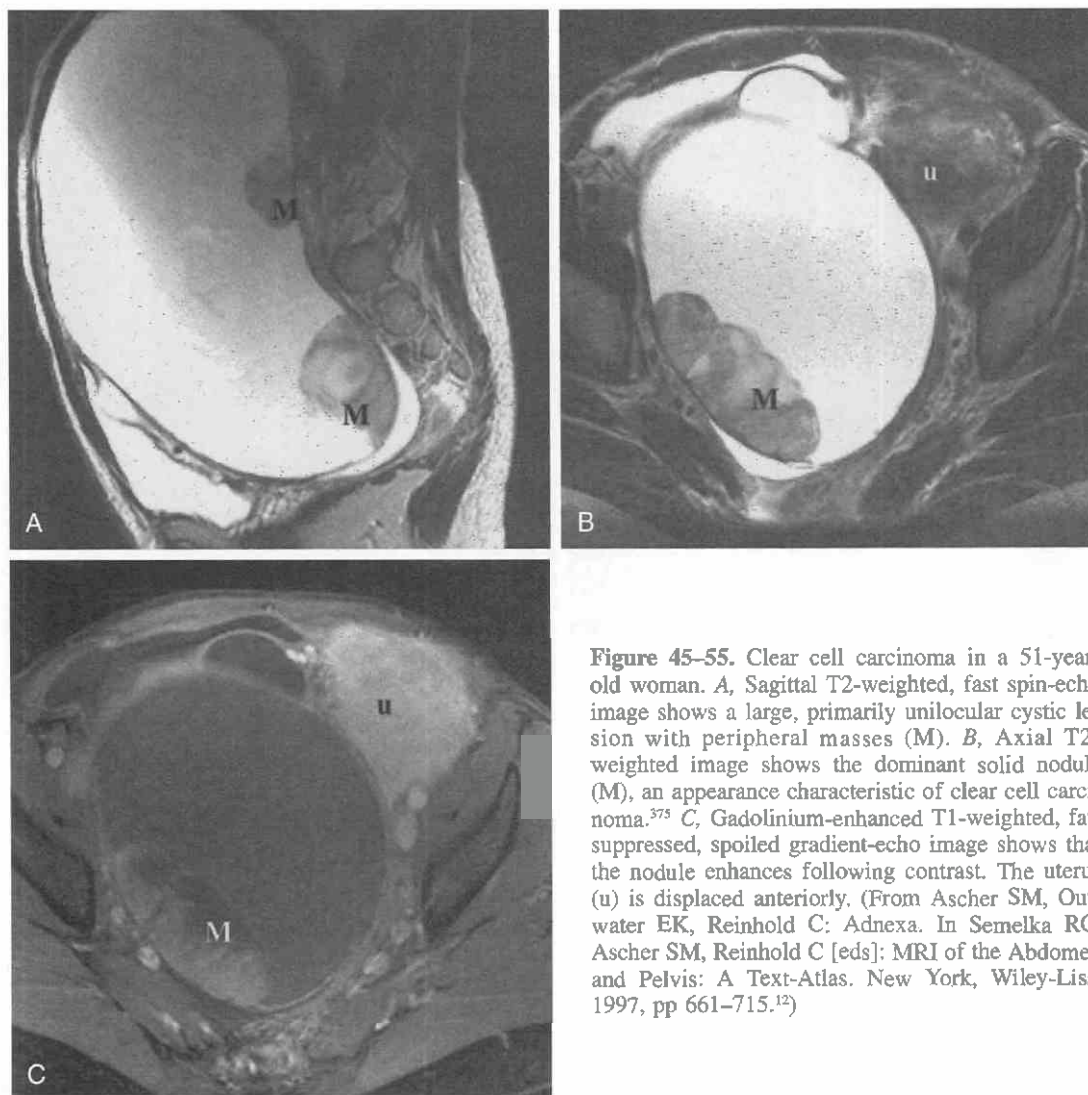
Clear cell carcinoma in a 51-year-old woman. *A*, Sagittal T2-weighted, fast spin-echo image shows a large, primarily unilocular cystic lesion with peripheral masses (M). *B*, Axial T2-weighted image shows the dominant solid nodule (M), an appearance characteristic of clear cell carcinoma.³⁷⁵ *C*, Gadolinium-enhanced T1-weighted, fat-suppressed, spoiled gradient-echo image shows that the nodule enhances following contrast. The uterus (u) is displaced anteriorly. (From Ascher SM, Outwater EK, Reinhold C: *Adnexa*. In Semelka RC, Ascher SM, Reinhold C [eds]: *MRI of the Abdomen and Pelvis: A Text-Atlas*. New York, Wiley-Liss, 1997, pp 661–715.¹²)
